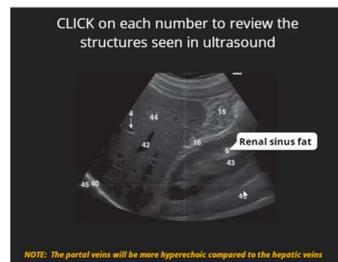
Example screenshot from the Cholecystectomy case. Students learn the ultrasound anatomy by clicking on the structures.
